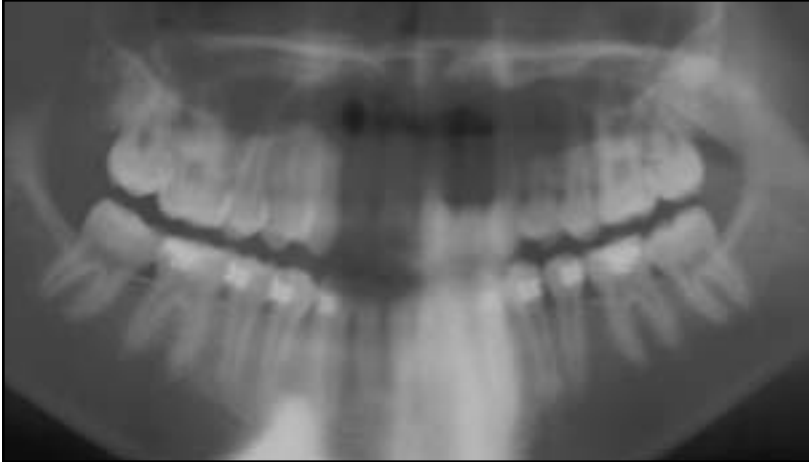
Panoramic radiograph taken after removal of fixed appliances, showing intact mandibular right second bicuspid root.
